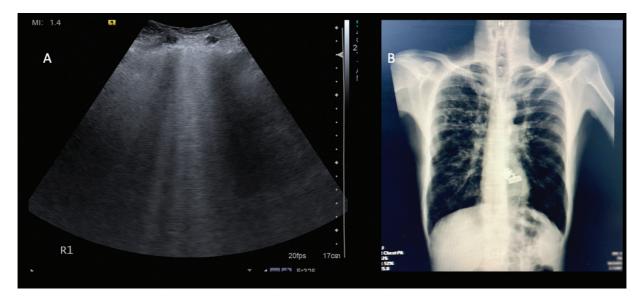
(A): Longitudinal gray-scale ultrasound scan of the right anterior chest along the midclavicular line, in the second intercostal space, in an elderly male patient presenting with dyspnea and cough revealed unilateral lung rocket pattern. Although the patient was afebrile, the pattern of unilateral lung rockets prompted a diagnosis of consolidation. However, chest X-ray (B) revealed fibronodular opacities in right upper zone. Bilateral lung fields were hyperinflated as well. The final clinical diagnosis at the time of discharge was acute exacerbation of COPD in a patient with old Koch's.
